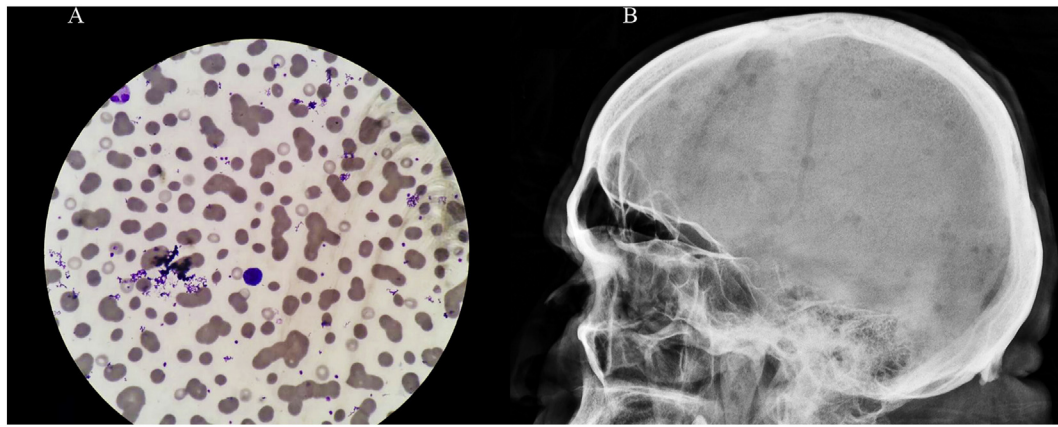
Panel A: peripheral blood smear showing erythrocyte rouleaux formation; Panel B: skull x-ray (lateral view) showing multiple punched-out lytic lesions.
